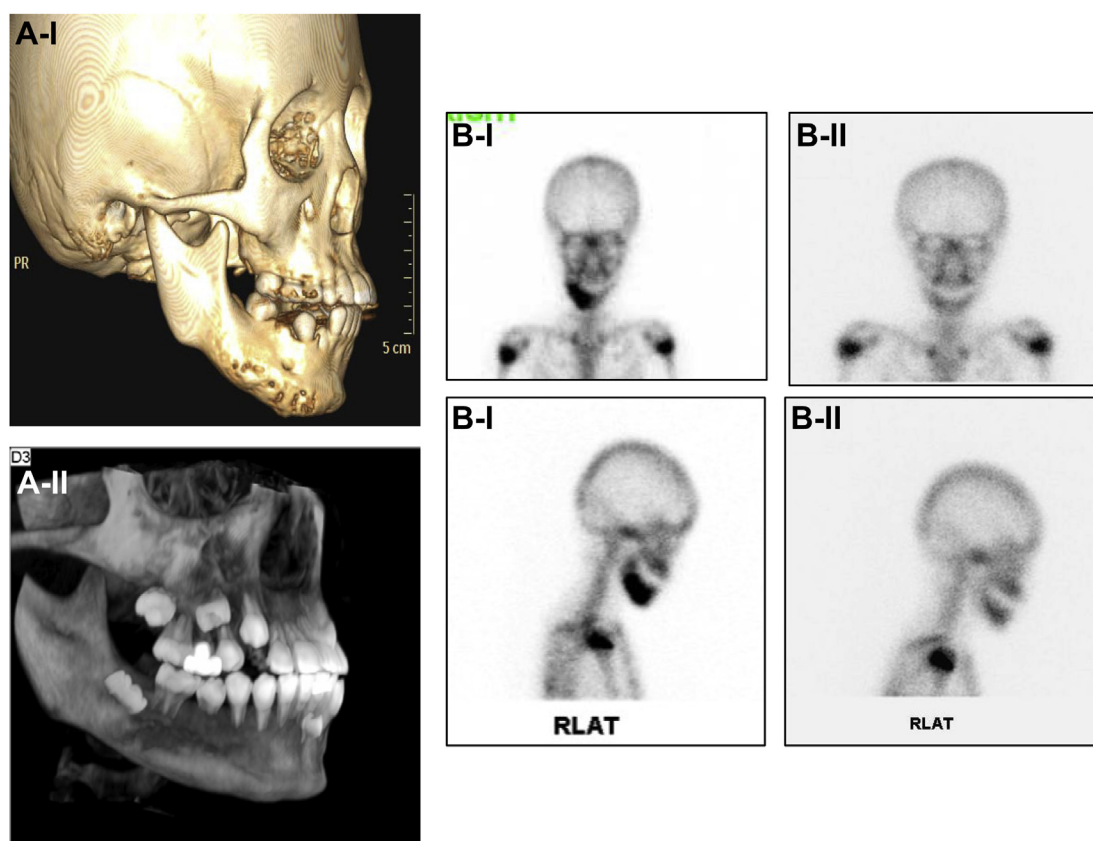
After 10 months, on a recall visit, a computed tomography scan demonstrated remodeling of the mandible, and the region that had shown increased tracer uptake had returned to normal on bone scanning. (A) Three-dimensional computed tomography imaging. (B) Whole-body bone scan images. I: at the first visit; II: at the 10-month follow-up.
